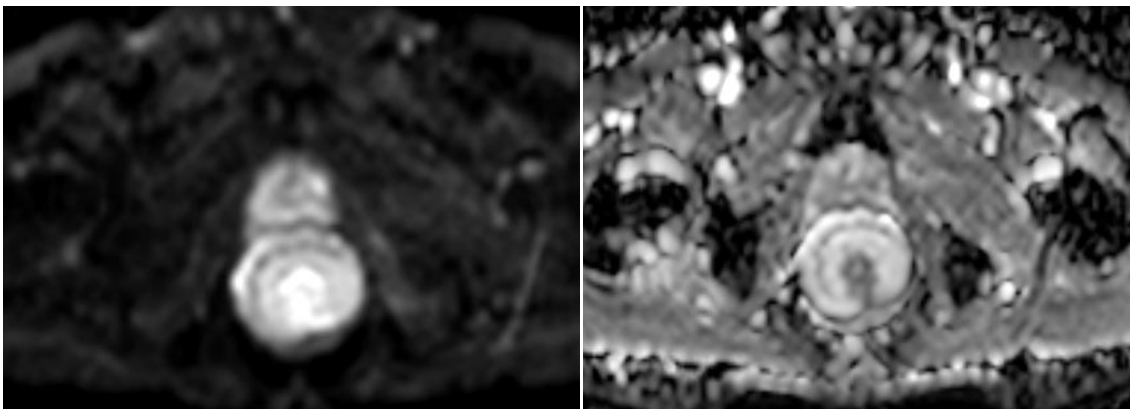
DWI of the tumour demonstrating T2 shine through effect (facilitated diffusion
